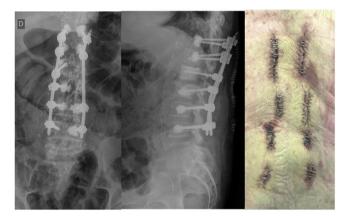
AP (left image) and lateral (central image) X-rays showing bilateral percutaneous cemented fixation D11–D12, right L1–L2, bilateral L3–L4, and percutaneous wounds (right image).
